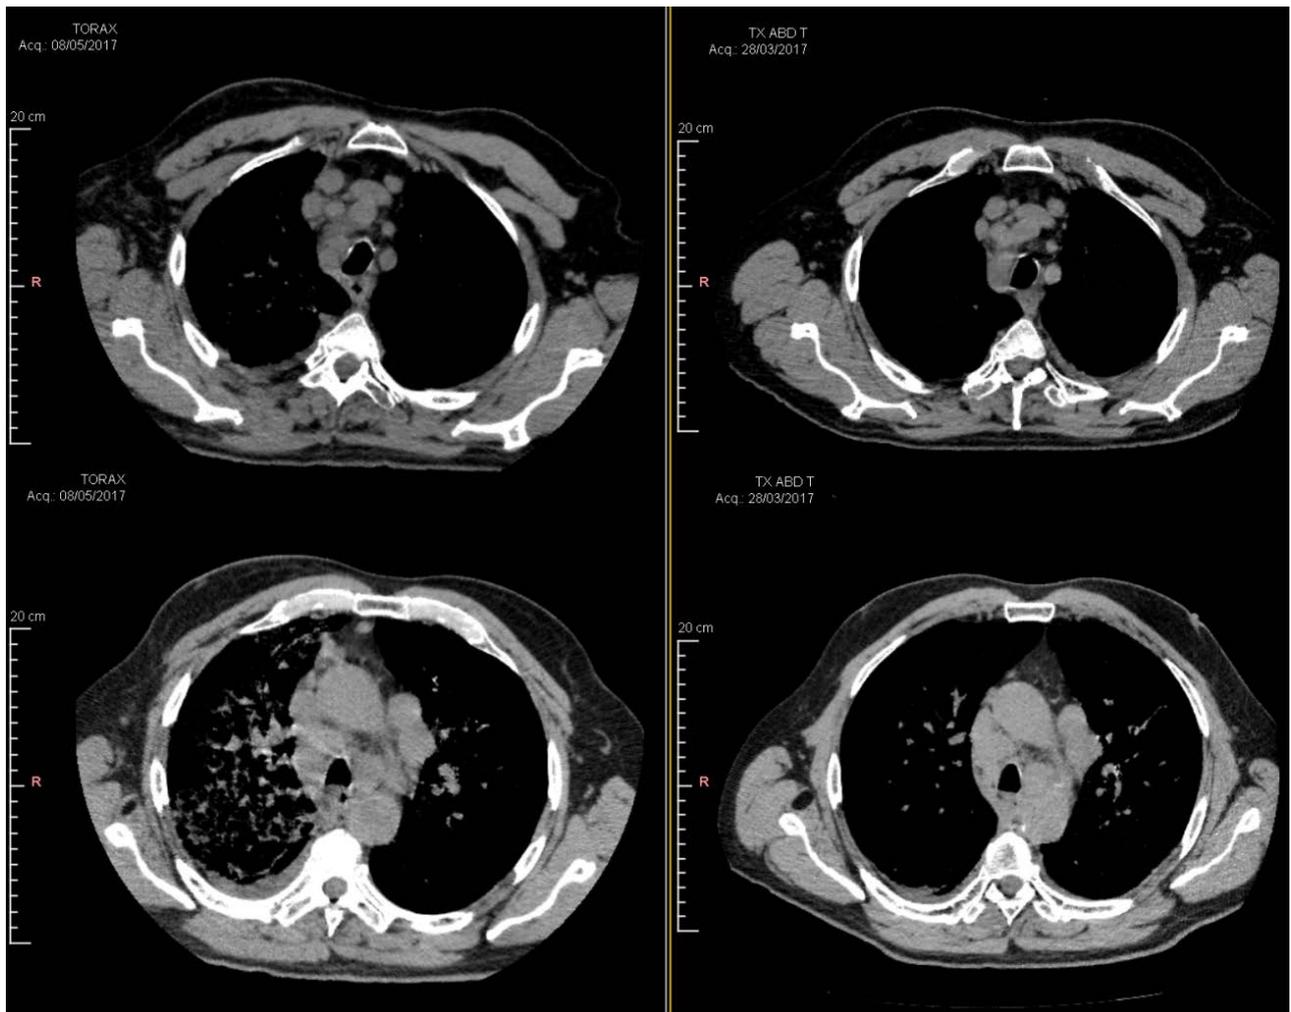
CT scan – Mediastinal window. Demonstrates of lymph node disease
